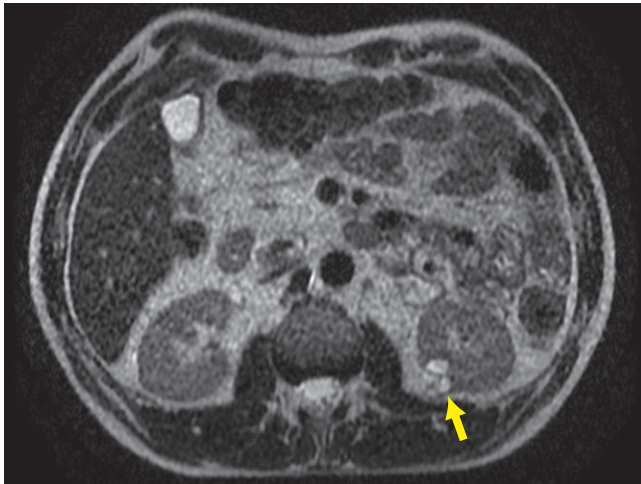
Attenuated MRI showing this multi-septated mass in the left kidney (arrow).
